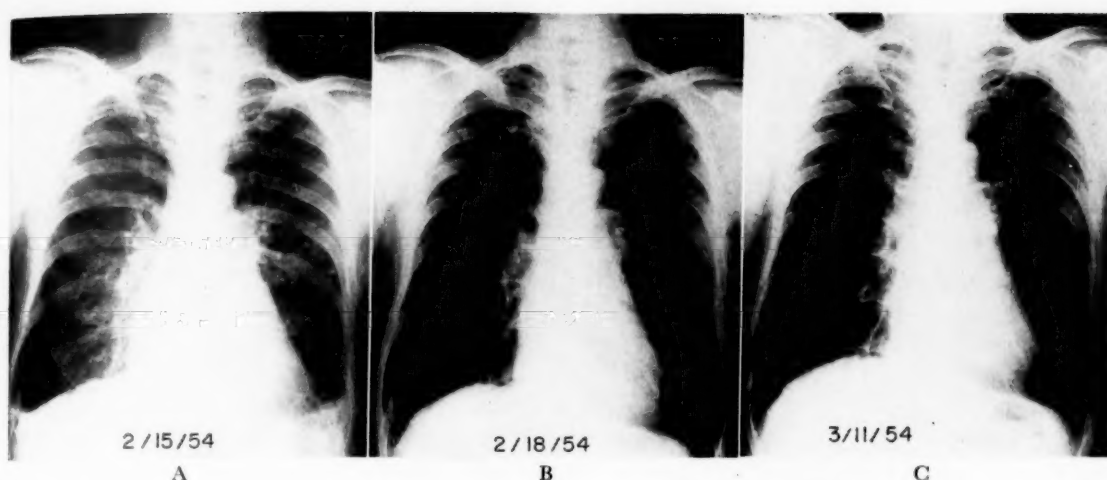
Case 4. Chest x-rays on second admission. (A) 2-15-54: Large heart, pulmonary congestion and pleural fluid. (B) 2-18-54: Digitalized; heart smaller and lungs clear. (C) 3-11-54: Rhythm regular after quinidine but no further reduction in heart size.
